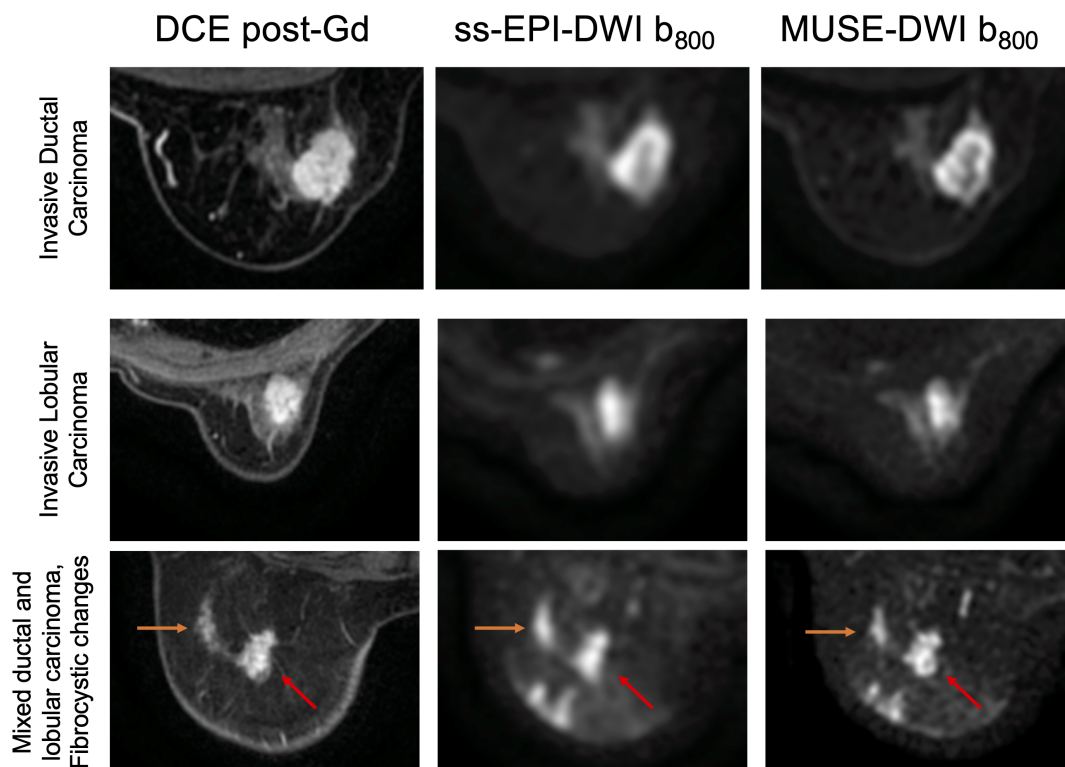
Post-gadolinium (Gd) DCE T₁W images, DWI using ss-EPI and DWI using MUSE for a 60 year old woman with invasive ductal carcinoma (top), a 63 year old woman with invasive lobular carcinoma (middle), and a 51 year old woman with an invasive carcinoma with mixed ductal and lobular growth patterns (red arrow) and columnar and fibrocystic changes with benign calcification (orange arrow) (bottom).
